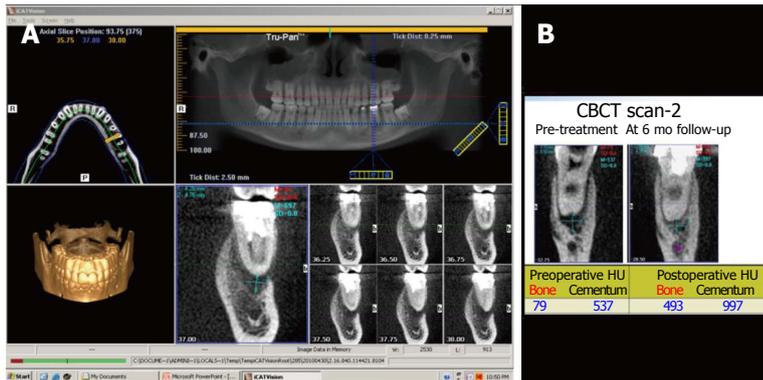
Cone beam computed tomography. A: A cone beam computed tomography scan gives a three-dimensional view of the area of interest. In this case, the periapical lesion is being evaluated; B: The image gives values in Hounsfield unit of cementum and alveolar bone density to measure post-treatment healing. CBCT: Cone beam computed tomography.
